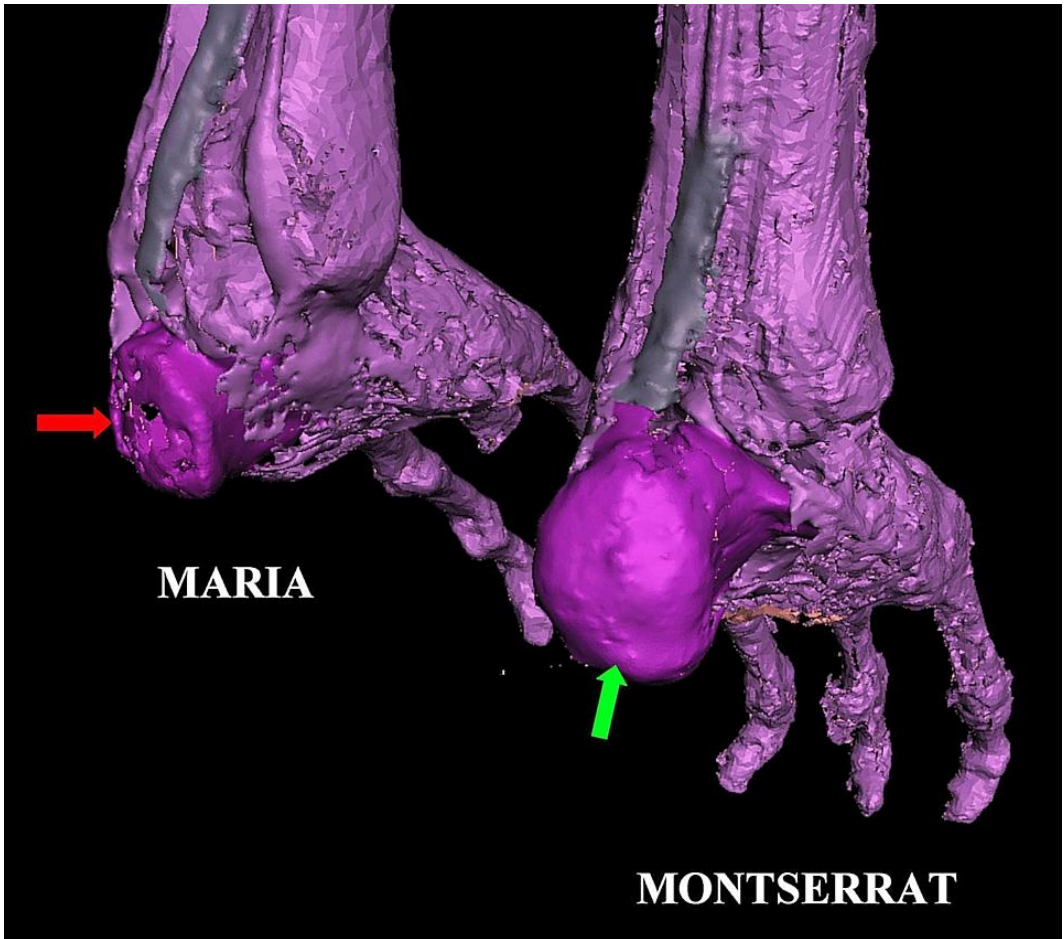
Comparison of 3D CT of Maria (*left*) and Montserrat (*right*) showing the truncated appearance in posterior part of the calcaneum (*red arrow*) in Maria contrasting with the rounded intact calcaneum (*green arrow*) in Montserrat. Also note the truncated Achilles tendon in Maria. The intact Achilles tendon in Montserrat can be traced to the calcaneal tuberosity.
